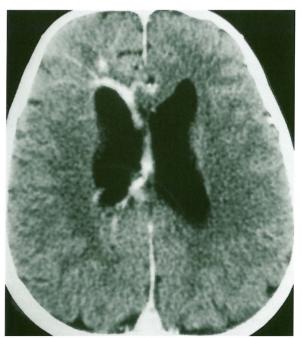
D-F) Contrast enhanced CT shows a large right frontal developmental venous anomaly (DVA) adjacent to the haematoma with subependymal drainage into the deep venous system.
